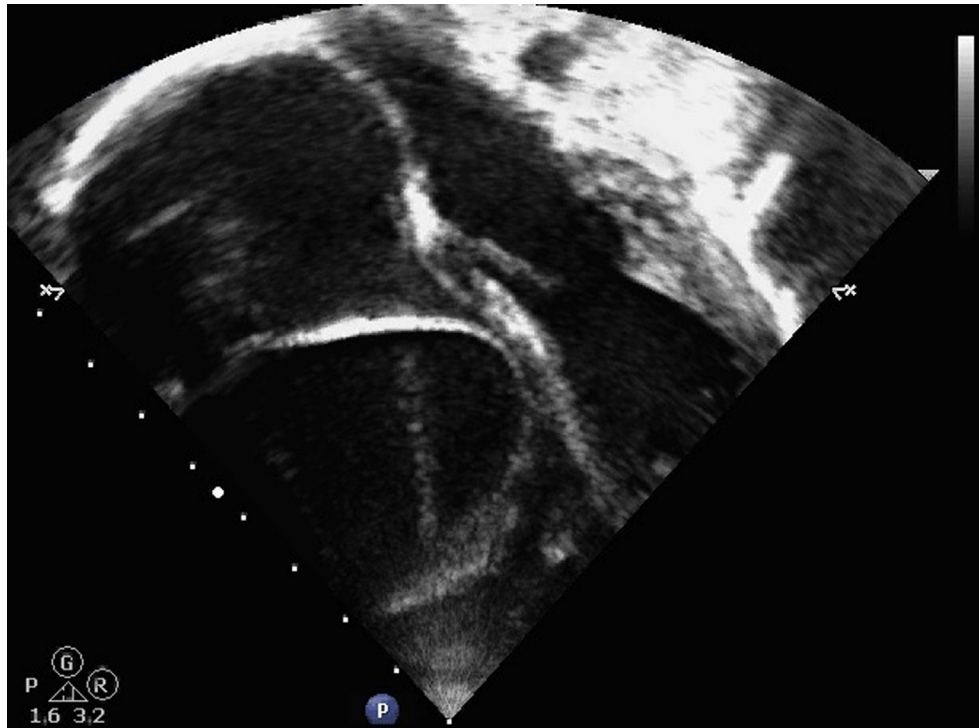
Transthoracic echocardiogram: apical four-chamber view showing the intramural hematoma/dissection flap in the atrialized right ventricle.
